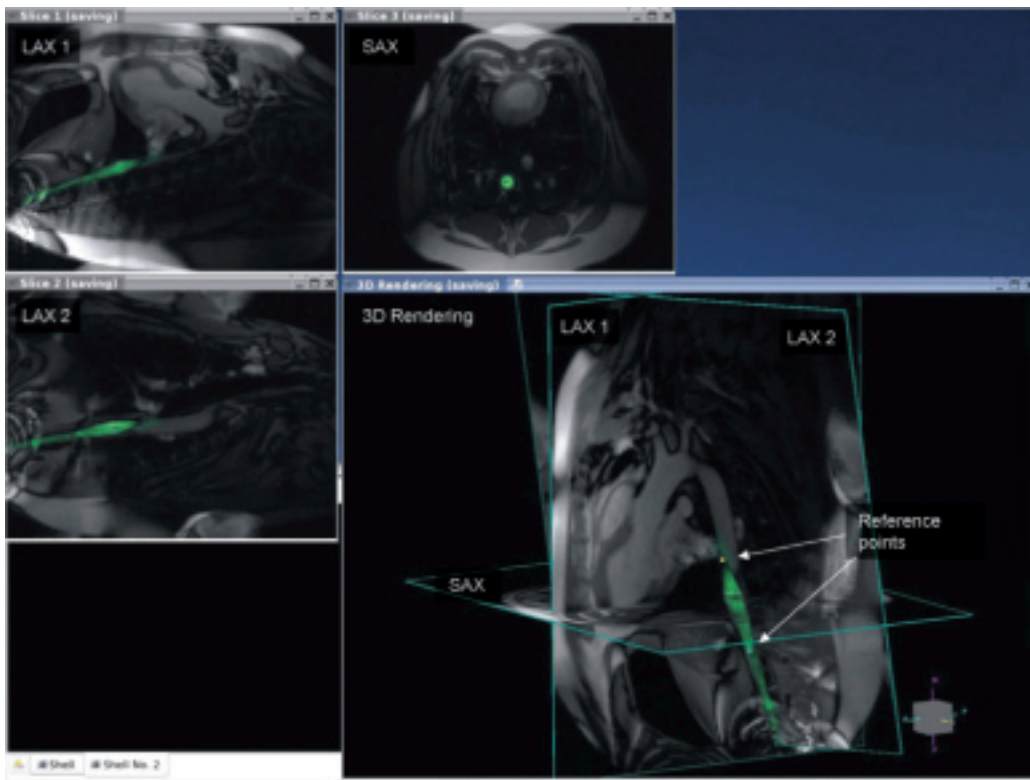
Example of using automatic catheter highlighting and reference image planes to navigate complex 3D anatomy using real-time MRI. The anatomic location of the catheter position on the image labeled
